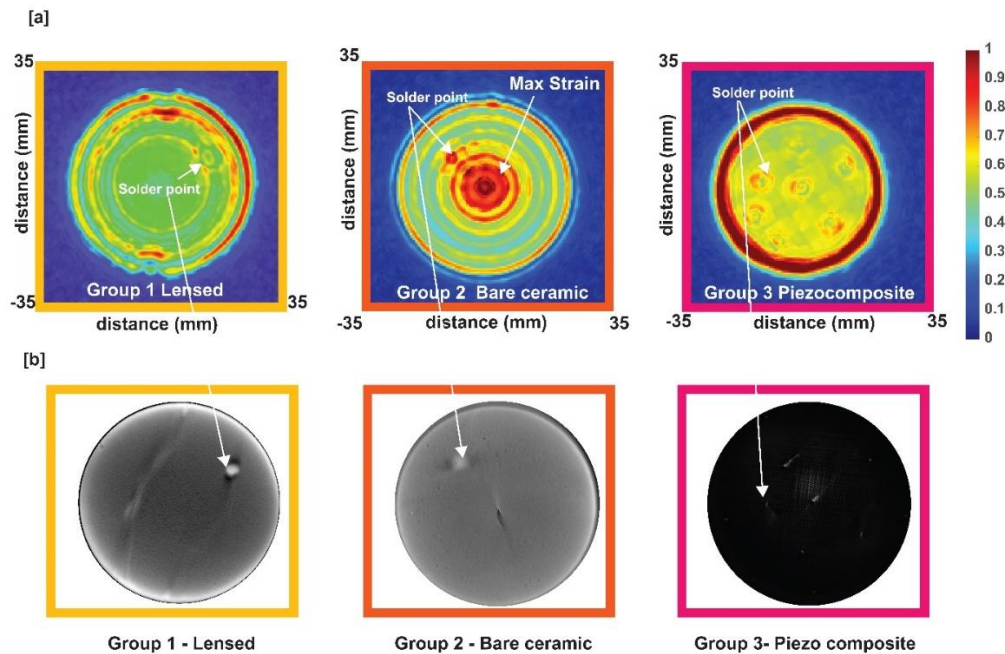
(a) Holography scans showing strain pattern across the surface of the transducer and corresponding Computed tomography scan.
